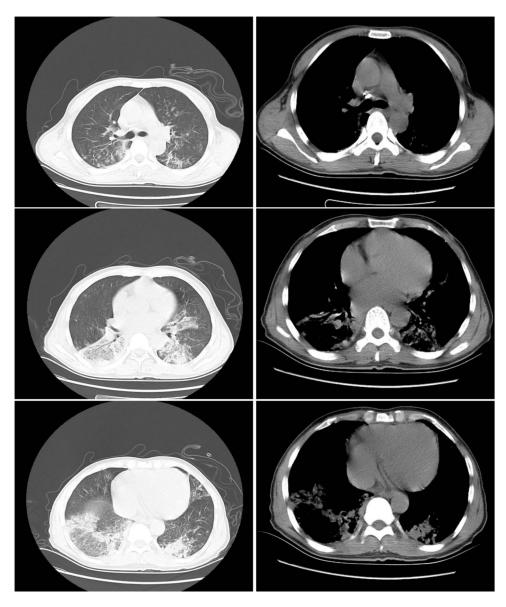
CT image of the chest after three weeks the treatment of pneumonia caused by Chlamydia abortus.
